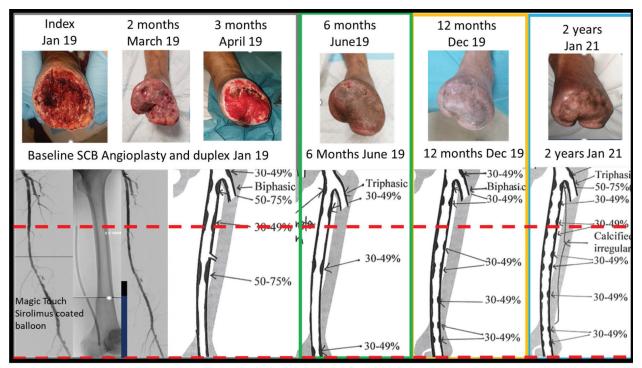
A patient from the XTOSI trial who received MagicTouch PTA to SFA. At 6 months, the wound was completely healed. At 2 years, the patient remained ulcer-free and duplex ultrasound demonstrated that the treated segment of SFA remained patent.
